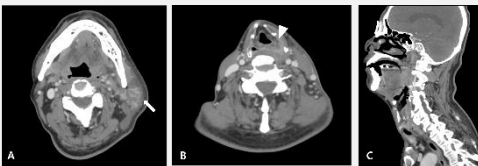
Neck CT performed to evaluate left chin swelling. (A) Axial image showing severe swelling of left parotid gland (arrow). (B) Axial image representing mild mucosal thickening of left hypopharynx (arrowhead). (C) Sagittal image showing hypopharynx and retropharyngeal space.
